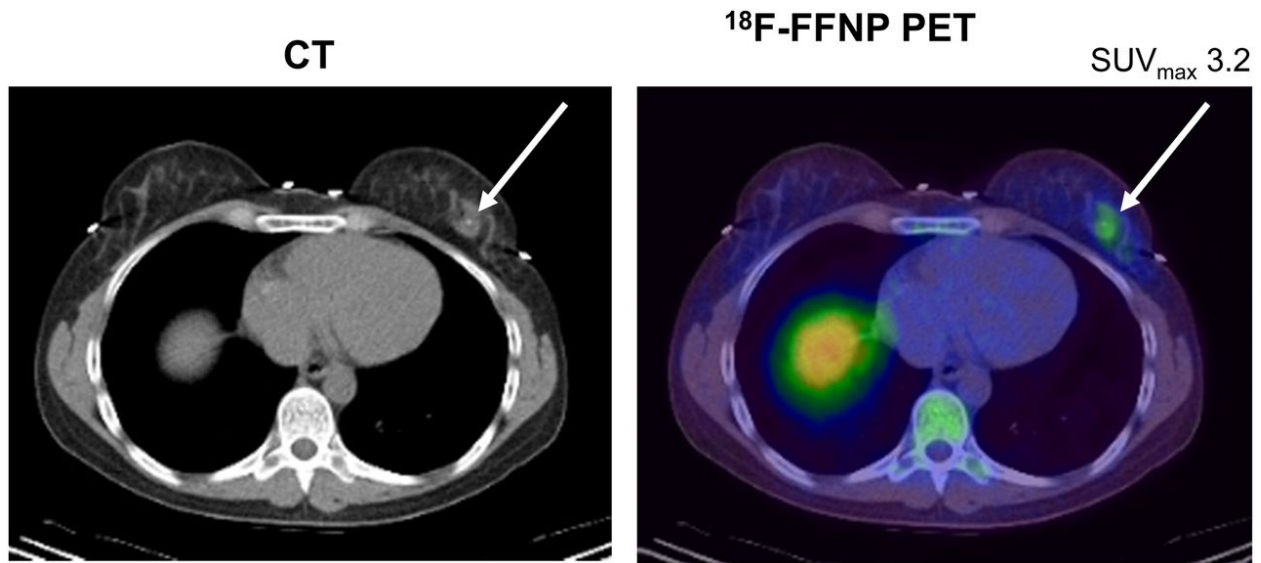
Axial PET/CT images demonstrate focally increased $^{21-18}\text{F}$ -fluoro- $16\alpha,17\alpha$ -[(R)-(1'- α -furylmethylidene)dioxy]-19-norpregn-4-ene-3,20-dione (FFNP) uptake in patient with biopsy-proven PR-positive left breast cancer (arrows). FFNP uptake can also be seen in the liver due to physiologic clearance. Reprinted with permission from Fowler AM et al, J Nucl Med.
